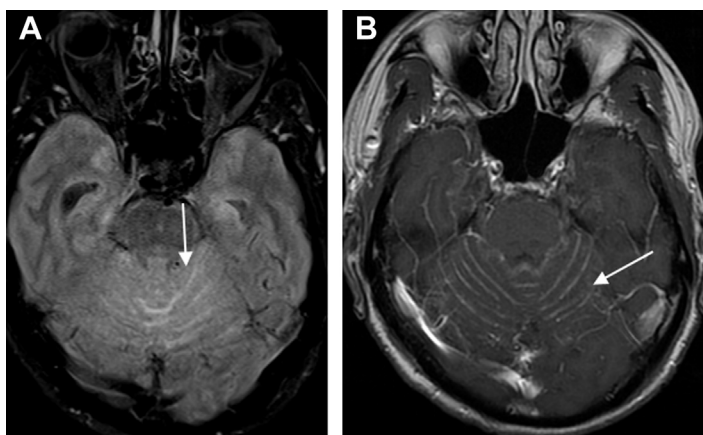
Breast cancer with NM. Axial FLAIR image (A) shows hyperintensity within the cerebellar folia (arrow) due to increased CSF proteinaceous content. Axial postcontrast T1WI (B) shows leptomeningeal enhancement along the folia (arrow).
